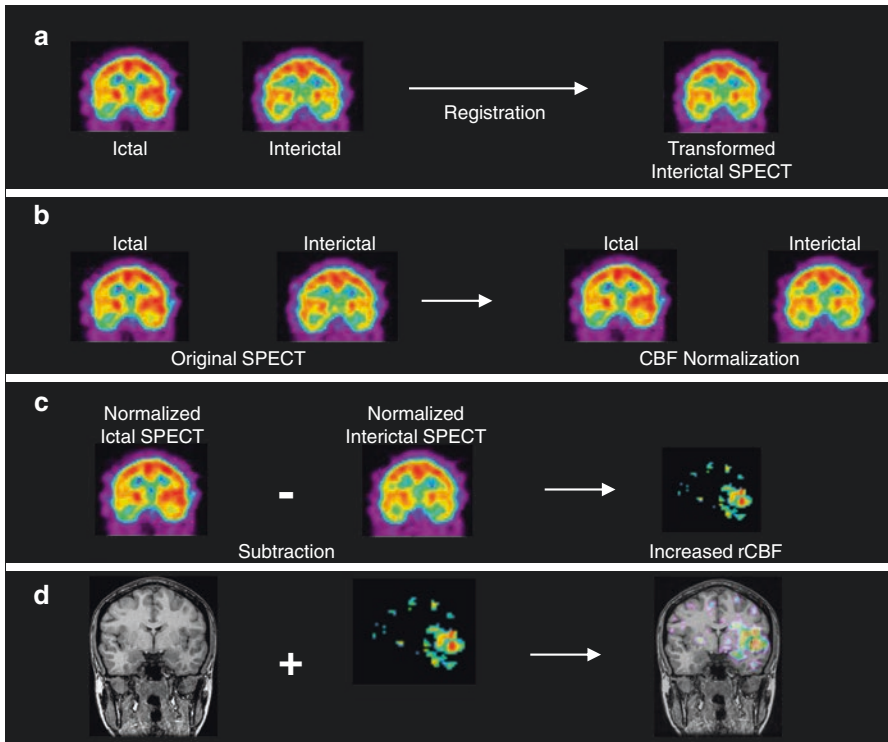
The process of subtraction ictal SPECT with coregistration to MRI. Interictal SPECT is linearly transformed to the same patient's ictal SPECT using chamfer surface matching algorithm (a). The total intensity levels of ictal and transformed interictal SPECTs are normalized (b). The difference of two corresponding pixel values of ictal and interictal SPECTs is calculated and separated into positive (increased rCBF) and negative difference (decreased rCBF) images (c). Finally, subtracted SPECT is overlaid to MRI for anatomical localization (d)
